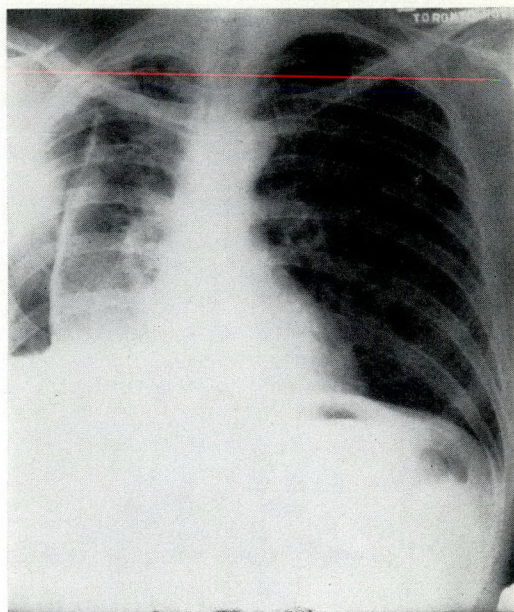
J.W. Chest radiograph May 24, 1966. After 29 years of pneumothorax, the right lung is inexpandable.
